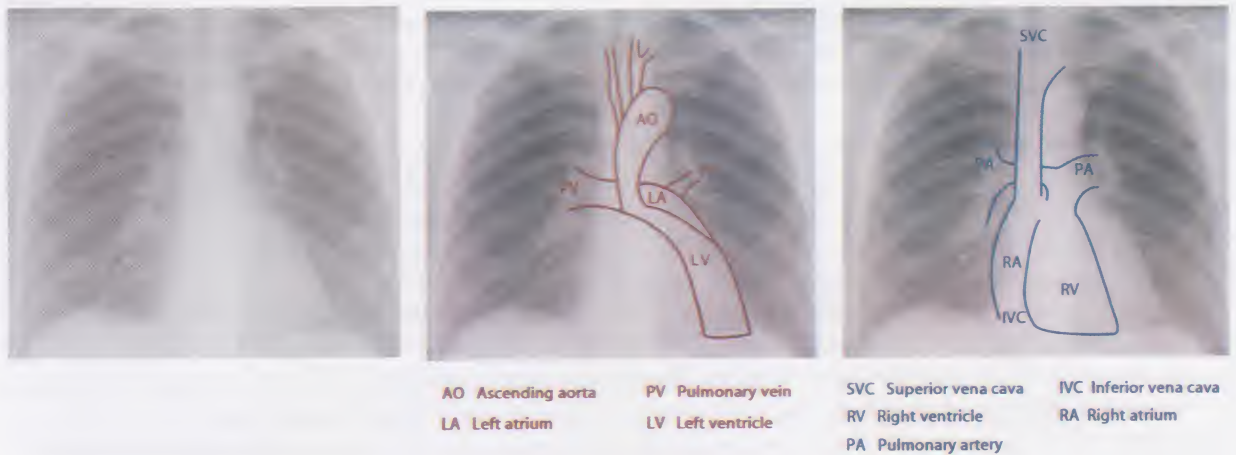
Normal PA chest x-ray
